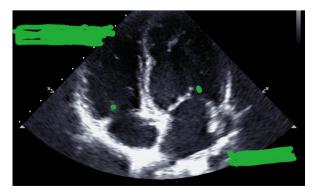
Cardiac ultrasound section showing aortic stenosis.
